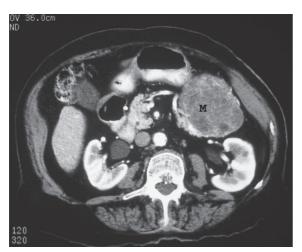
Microcystic adenoma in a 75-year-old female. CT shows a well-defined mass (M) at the pancreatic tail. This mass is composed of multiple small cysts of less than 2 cm.
